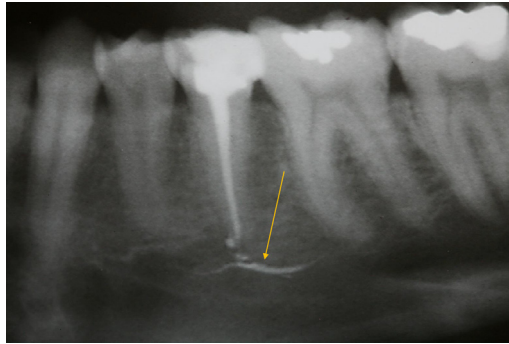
Arrow in radiograph showing injury to the inferior alveolar nerve after the introduction of endodontic filling into the inferior alveolar canal.
